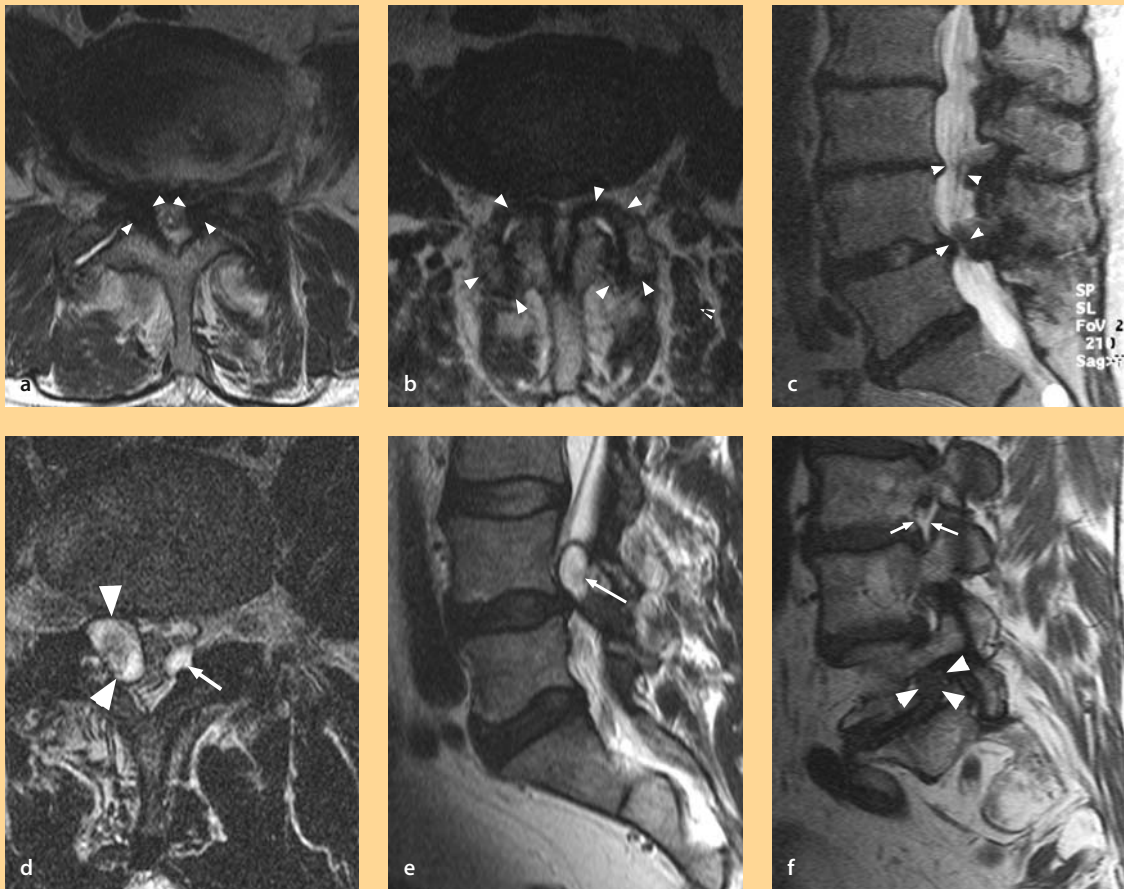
MRI characteristics of spinal stenosis
